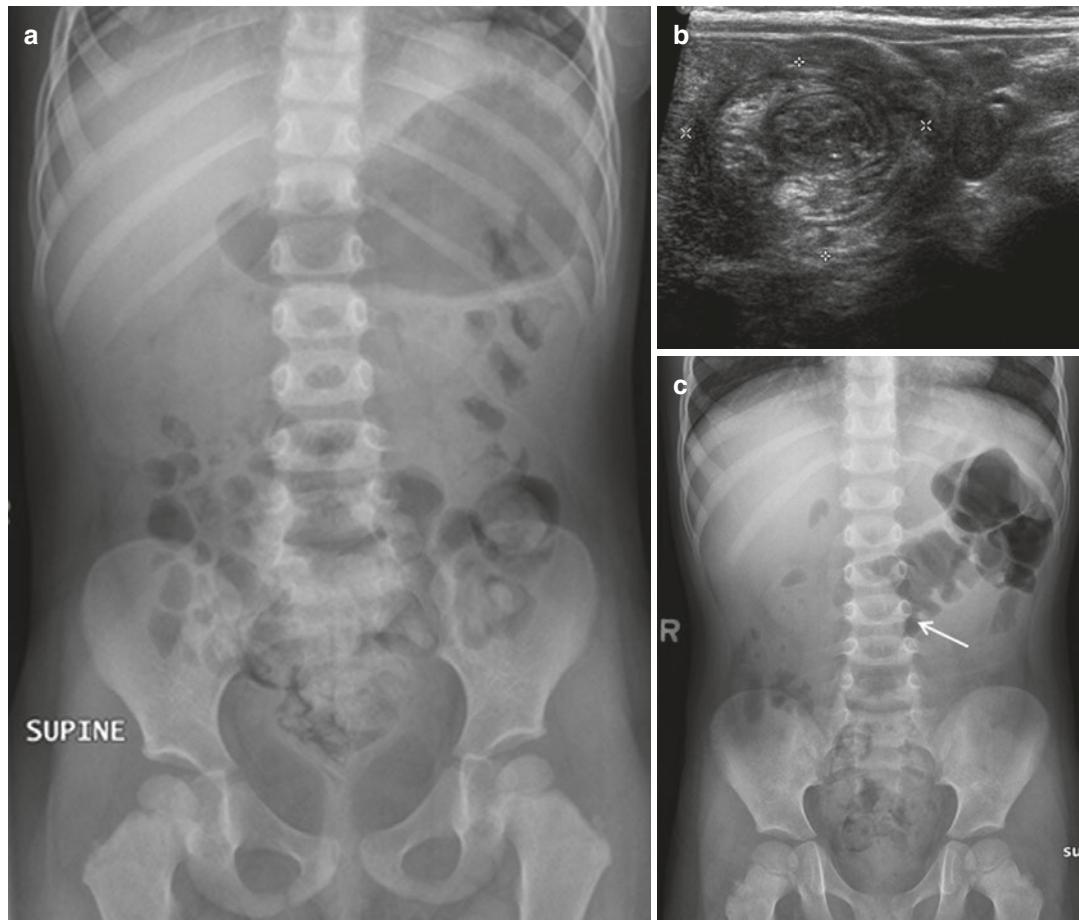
(a) Supine abdominal radiograph of a 2-year-old girl with colicky abdominal pain shows no specific bowel abnormality. (b) Ultrasound of the same patient demonstrates an ileocolic intussusception. (c) Supine
